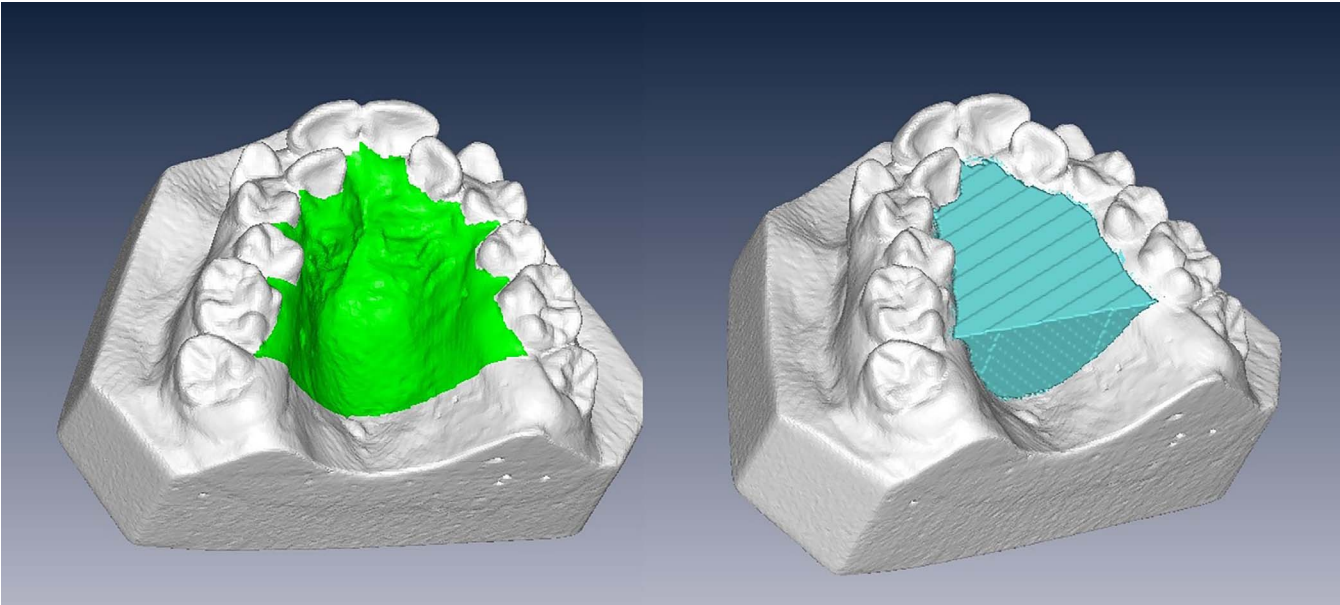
Area and volume measurements on CBCT digital cast models. CBCT indicates cone beam computed tomography.
